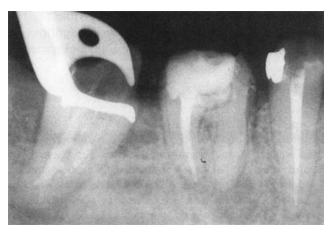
Radiograph taken after down-packing the C-shaped canal showing communication with the mesiobuccal canal.
